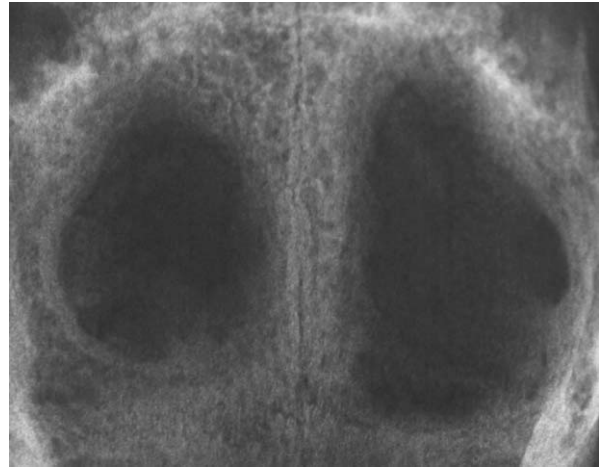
Postsacrifice radiograph showing defects bilaterally in the parietal bones.
